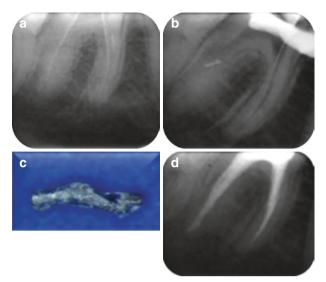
Transportation of a fragment deeper into the root canal. (a) Preoperative radiograph. A 6 mm fragment of a #25 Hedstrom file can be seen at the coronal third of the mesiobuccal canal of the first mandibular molar. During retrieval attempts, a 1.5 mm segment of the original fragment was broken and removed, but the remaining part was inadvertently pushed apically. (b) The remaining portion was eventually bypassed with the file bypass technique and the root canal was instrumented and obturated up to the apex incorporating the fragment in the mass of gutta-percha
